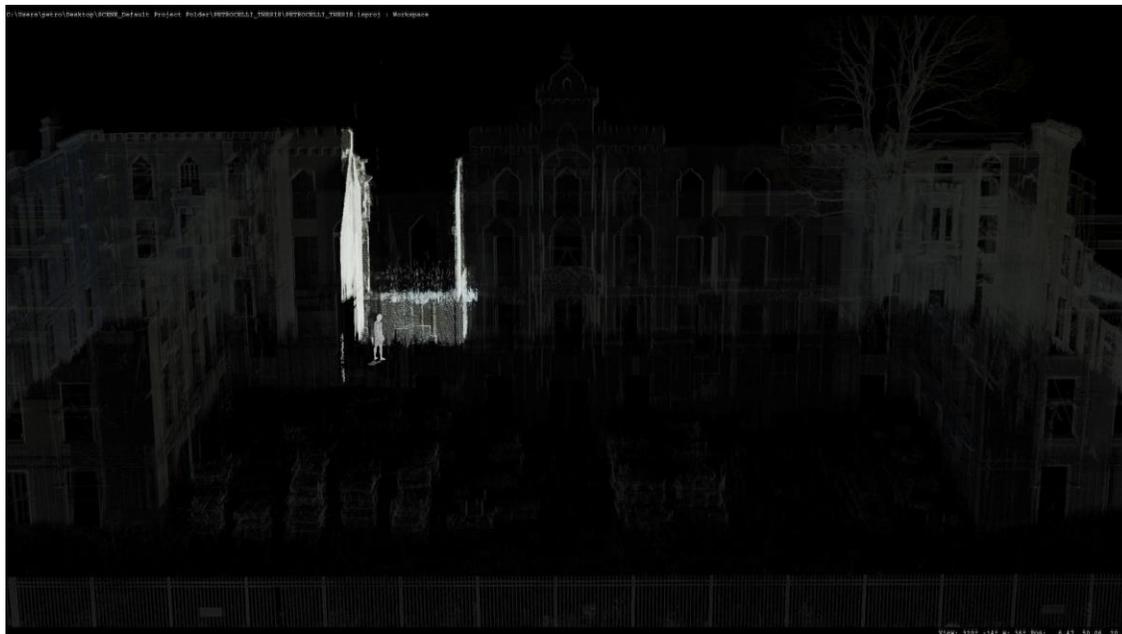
Framed Contrast; Smallpox Hospital Xray
